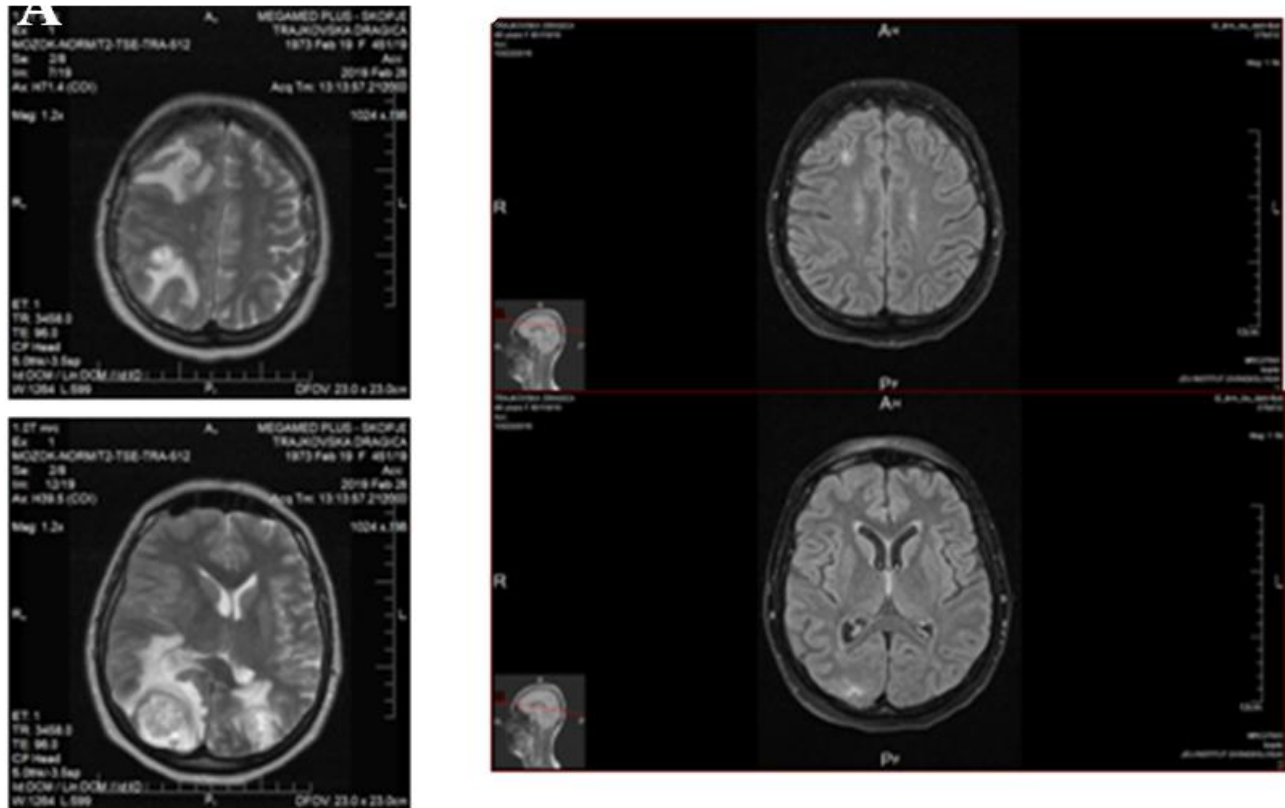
Magnetic resonance imaging scans depicting the response of intracranial metastases after alectinib treatment (A pretreatment metastatic foci, B positive response to the alectinib after 9 months)
